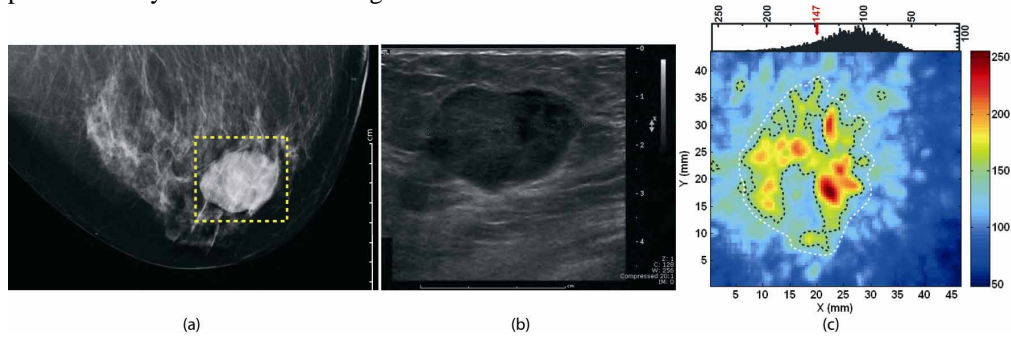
Case 2 of 57 year old woman with invasive ductal carcinoma exhibiting neuroendocrine differentiation in right breast. Gross features in craniocaudal x-ray mammogram (a) and transverse sonographic scan image (b) indicate benignity, but presence of microcalcifications in (a) and age of patient prompted core biopsy. Craniocaudal photoacoustic MIP image (c) in ROI (red window in x-ray mammogram) shows high intensity distributions in a ring shape attributable to higher vascular densities at tumor periphery. Contour lines (black dotted) are superposed using level indicated in the image histogram above. The photoacoustic image cannot be compared point by point with the x-ray image in ROI due to differences in compression and in ROI positioning.
